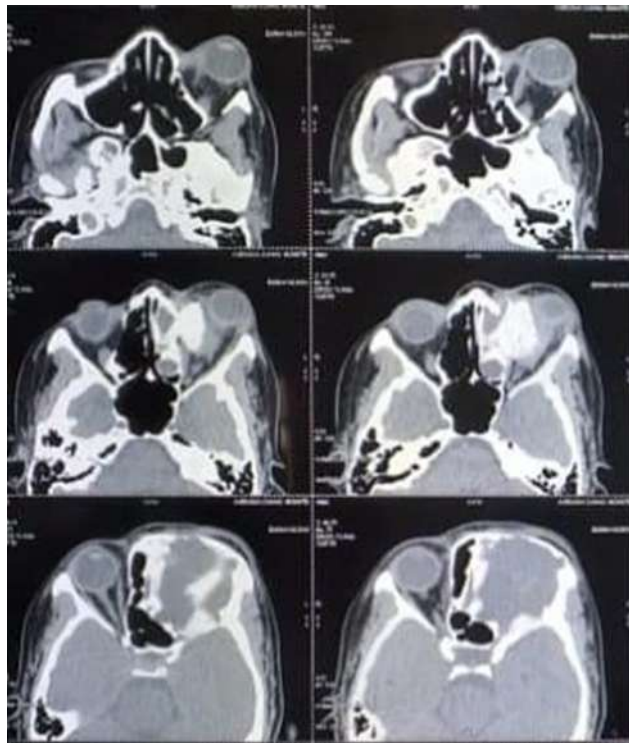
Preoperative CT Scan
